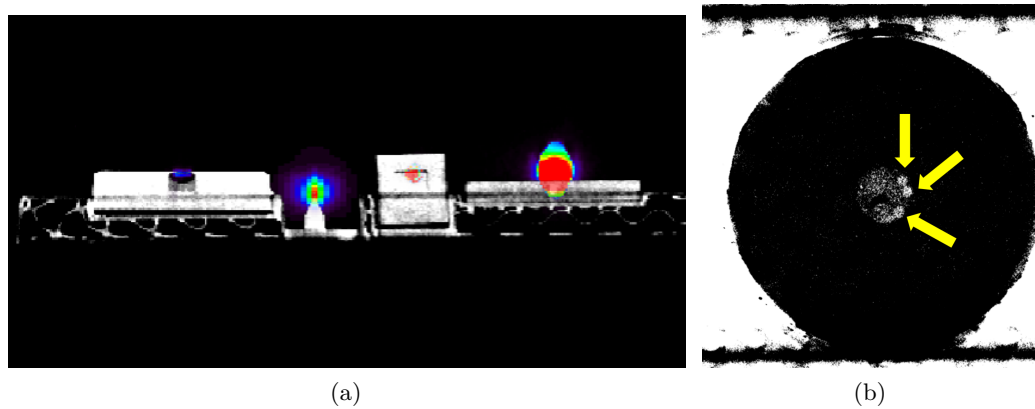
a) 2D slice of the PET of the point sources overlaid on the high-resolution CT image obtained using the MEDISO scanner. b) The CT slice of a disk sources (first disk from left in 4.14a) showing the radioactive seeds (yellow arrows).
